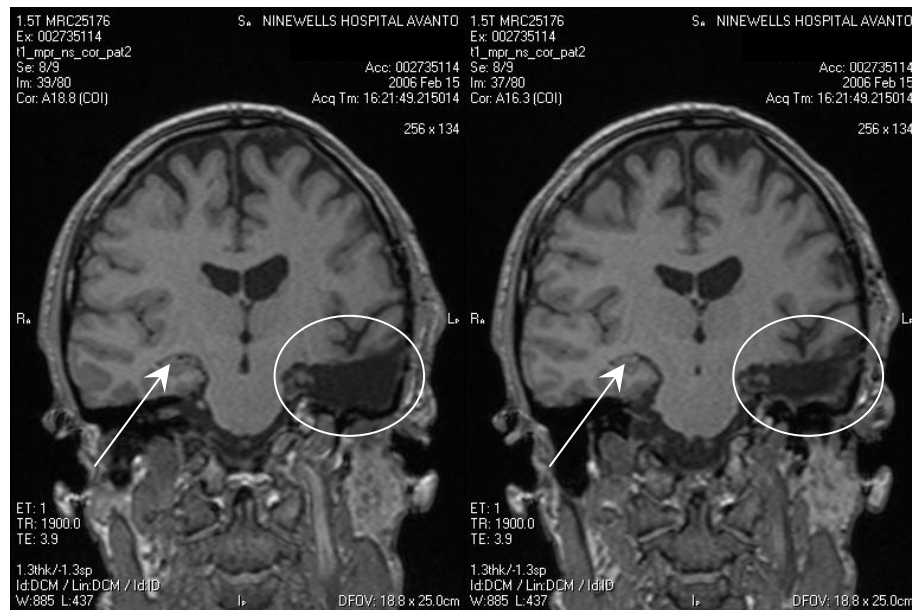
T1 coronal MRI scan of NM's brain (left and right reversed). The circle indicates the surgical excision from the left temporal lobe including the left hippocampus. The intact right hippocampus is indicated via the arrow.
